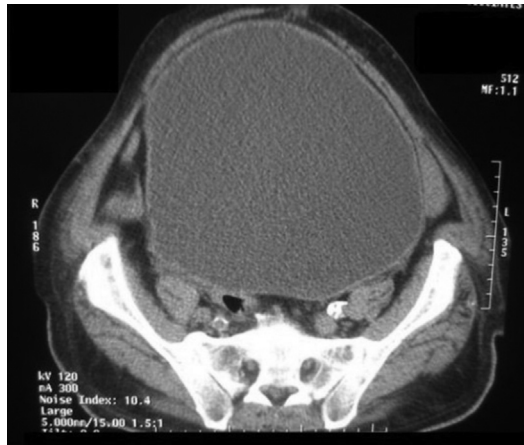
CT scan: severely distended urinary bladder secondary to urinary retention. (From Sharma A, Naraynsingh V. Distended bladder presenting with constipation and venous obstruction: a case report. *J Med Case Rep* 2012;6:34.)
